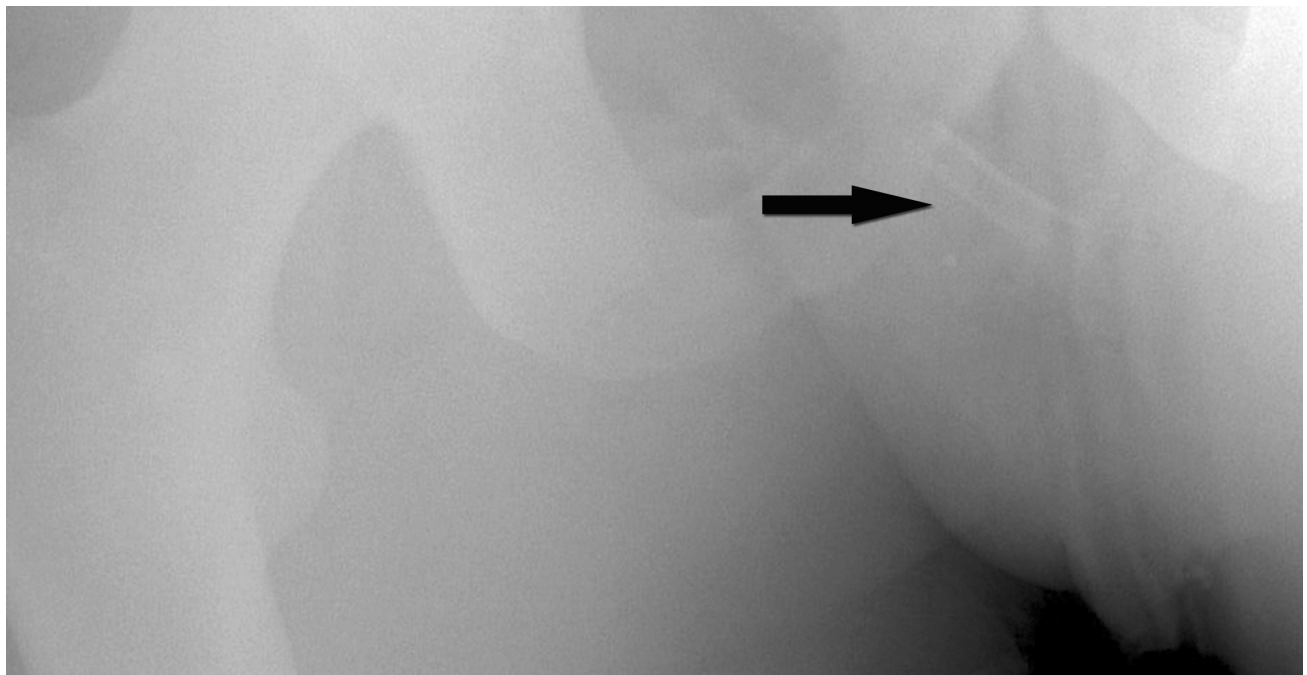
Coned pelvic radiograph demonstrates foreign body overlying the right pubic ramus (arrow).*
